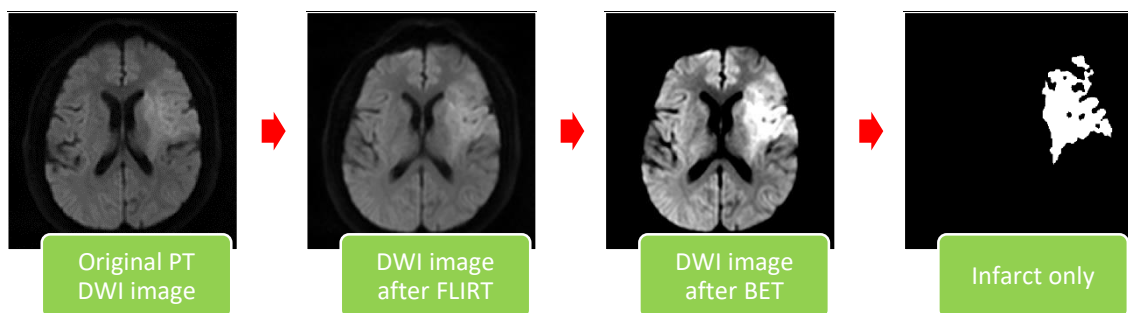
Steps involved in obtaining the infarct image from PT DWI images.
